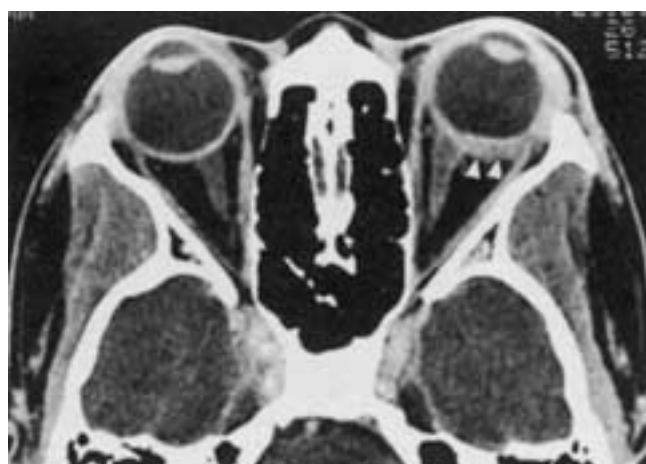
Posterior scleritis. Enhanced axial CT scan shows thickening with enhancement of the posterior scleral-uvular coat (*arrowheads*). (Courtesy of M.F. Mafee, MD, FACR, Chicago.)
